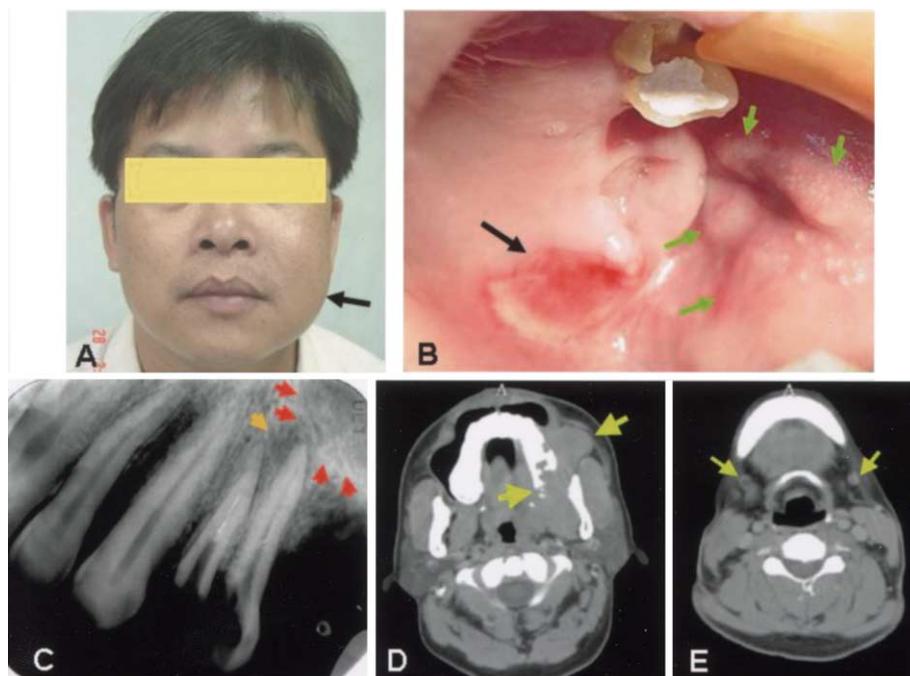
(A) A painful swelling was noted over the patient's left cheek (arrow). (B) An ulceration over the left tuberosity (black arrow) and a painful, tender swelling over the left buccal mucosa (green arrows) were also observed. (C) Periapical radiography revealed an apical lesion over residual root of tooth 25 (yellow arrow). An inconspicuous poorly defined radiolucence was found over the distal aspect of tooth 25 (red arrows). (D) Computerized tomography (CT) revealing extensive soft-tissue lesions involving the left nasopharyngeal space, maxillary sinus, infra-temporal fossa, oropharyngeal space, palate, parapharyngeal space and the buccal space and resulting in the bony destruction of the maxilla, the wall of the maxillary sinuses and the mandibular ramus (arrows). (E) Bilateral submandibular nodal involvement was suspected upon CT scan investigation.
